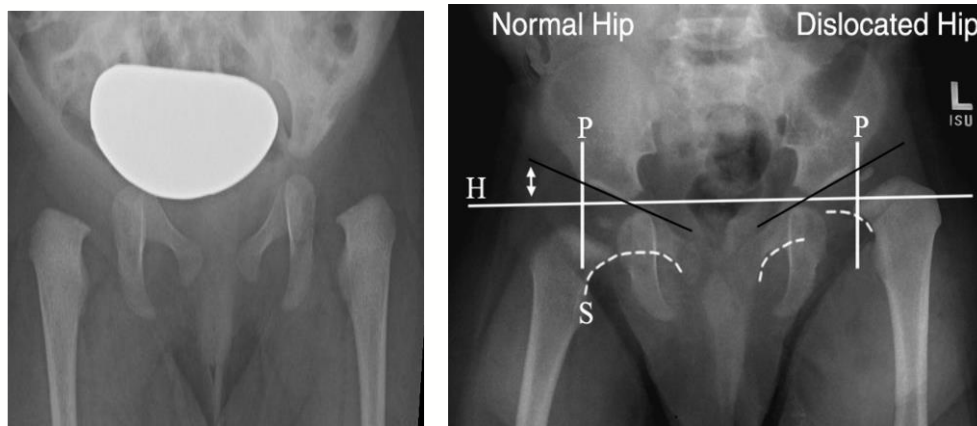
Radiograph of a 3-month-old child showing radiological signs of D.ZHK.
